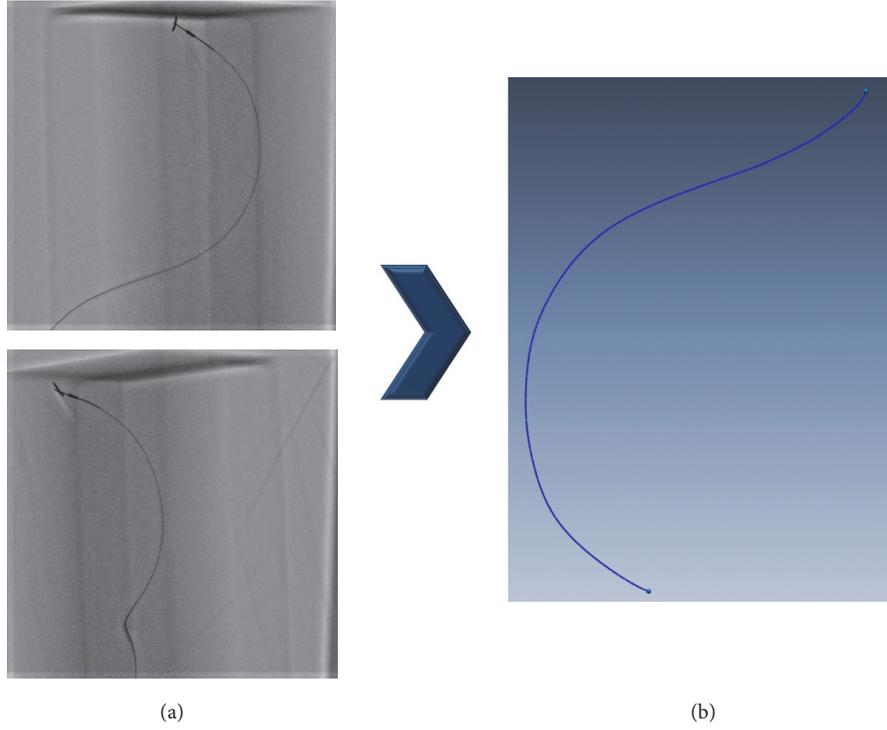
(a) Biplane X-ray angiogram images of IVUS catheter. (b) Restored IVUS catheter path in 3D space.
